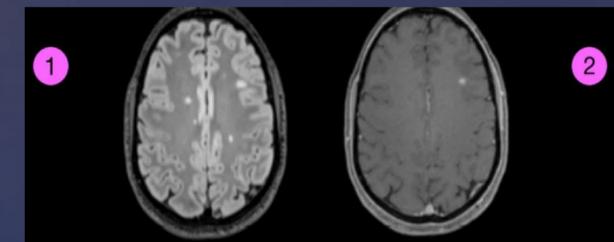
The MRI scan labeled number 1 was taken without the use of a contrast agent. Old MS plaques are visible as white spots. The MRI scan labeled number 2 was taken after gadolinium administration. One new MS plaque is highlighted due to leaky blood vessels.³
